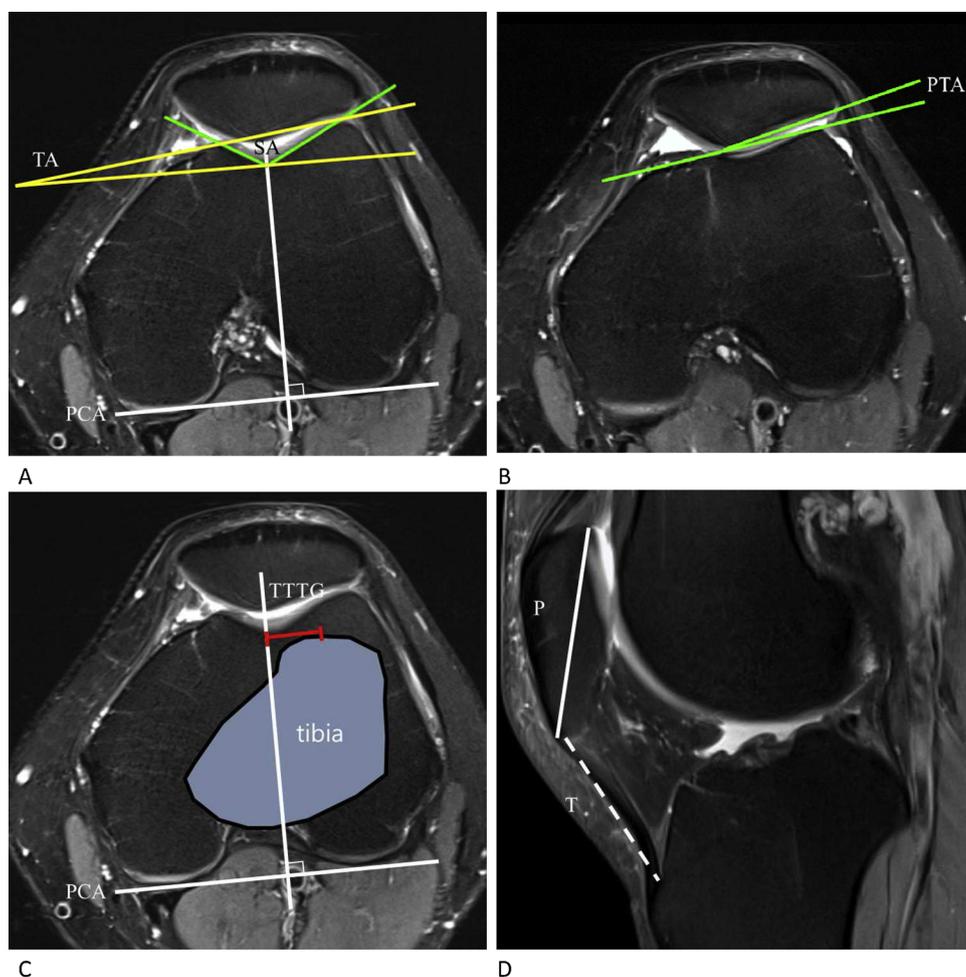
MR images to measure patellofemoral maltracking parameters. (A) The section with the posterior-most condyle is selected. The trochlear and sulcus angle areas are then drawn based on both the posterior condylar axis and the lines between the bony cortex of the femoral trochlea. (B) The section with the greatest patellar width is selected. The patellar tilt angle is then drawn based on both the line tangential to the anterior condyles and the line parallel to the bony lateral patellar facet. (C) Tibial tuberosity-to-trochlear groove distance is measured as the distance from the mid-trochlear groove to the midpoint of tibial tuberosity, parallel to the posterior condylar axis. (D) The section with the greatest diagonal patellar length selected (P, solid line), and the distance of the patellar tendon from the inferior patellar pole to the tibial tuberosity (T, dashed line) is then measured. Insall–Salvati ratio was calculated as T/P. P, patella; PCA, posterior condylar axis; PTA, SA, sulcus angle; TA, trochlear angle; patellar tilt angle; TTTG, tibial tuberosity-to-trochlear groove distance; T, patellar tendon.
